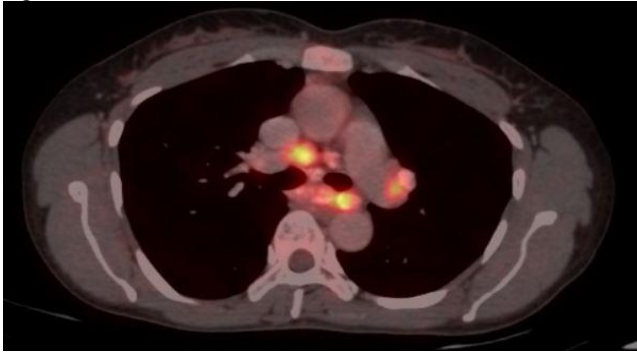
PET-CT showing metabolically active disease in multiple mediastinal nodes.
